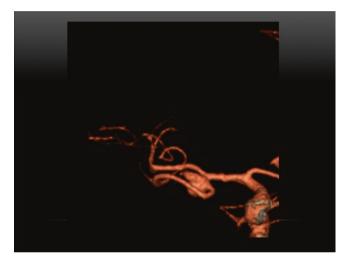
Three-dimensional computed tomography angiography in a 65-year-old woman demonstrates a right middle cerebral artery bifurcation aneurysm
